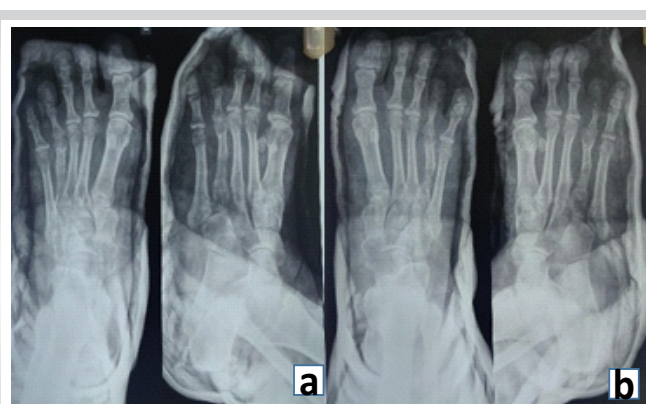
Post-exit X-ray after 2 months. (a) Left foot anterior posterior view and oblique view with callus formation in the distracted phalanx after external fixator exit. (b) Right foot anterior posterior view and oblique view with callus formation in the distracted phalanx after external fixator exit.
